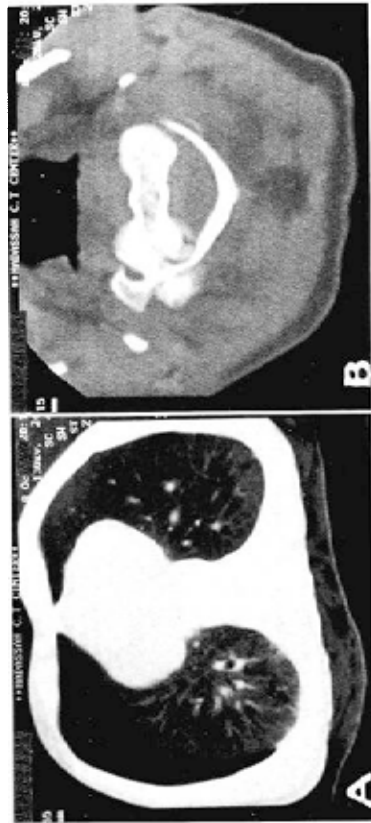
Postmortem computed tomographic scan carried out 6 hours after death. (A) Obvious right and small left pneumothorax; (B) comminuted fracture of C-2.
